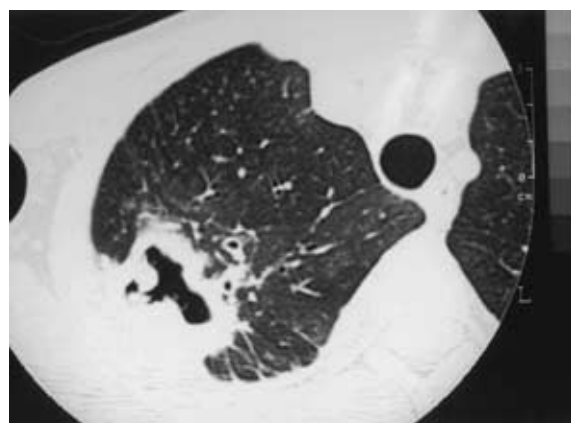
Computed tomography of the chest shows nodular shadows protruding into the cavity.
